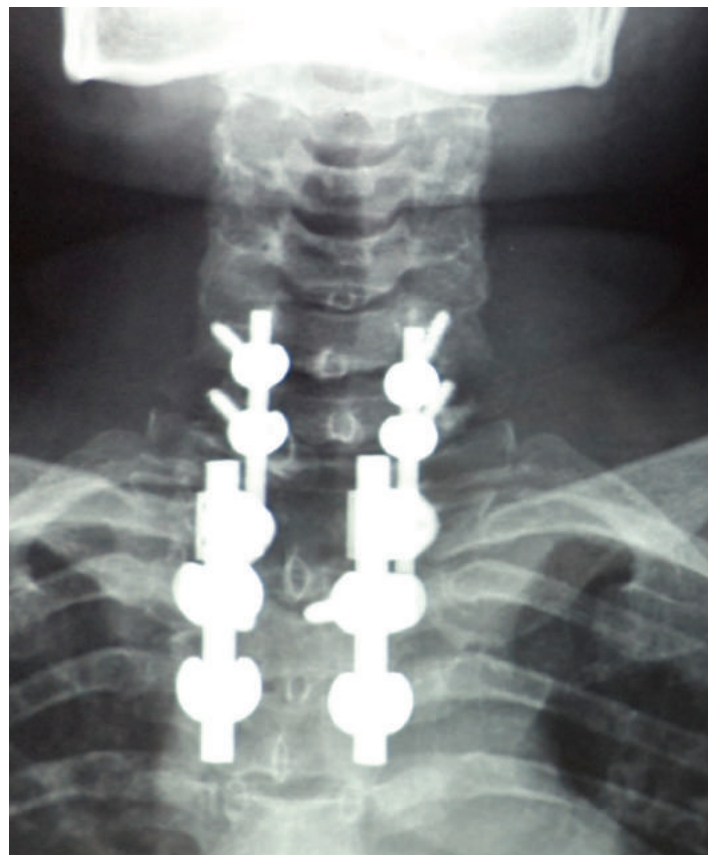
Cervical X-ray Post Debridement and Stabilization with Lateral Screw
